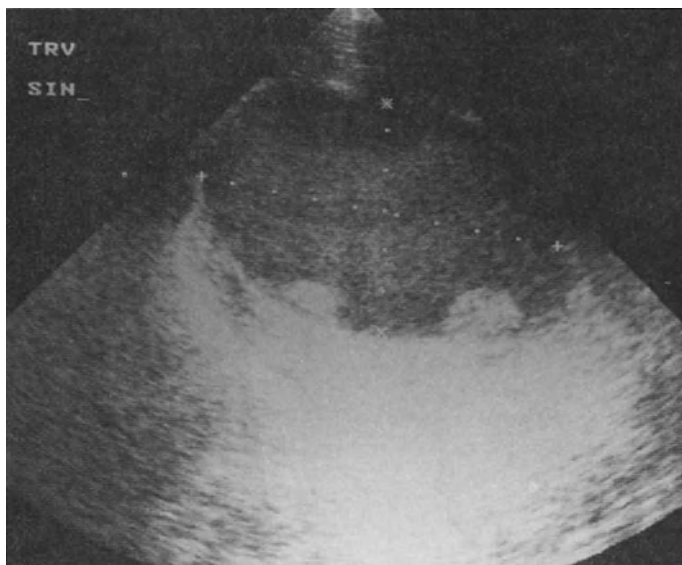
Ultrasound as a guide for biopsy: Malignant fibrous histiocytoma. At ultrasound examination, tumor nodules are seen adjacent to the capsule. The central area of homogenous echogenicity represents a large hematoma. If biopsy is performed, it should be directed towards the tumor nodules in the periphery.
